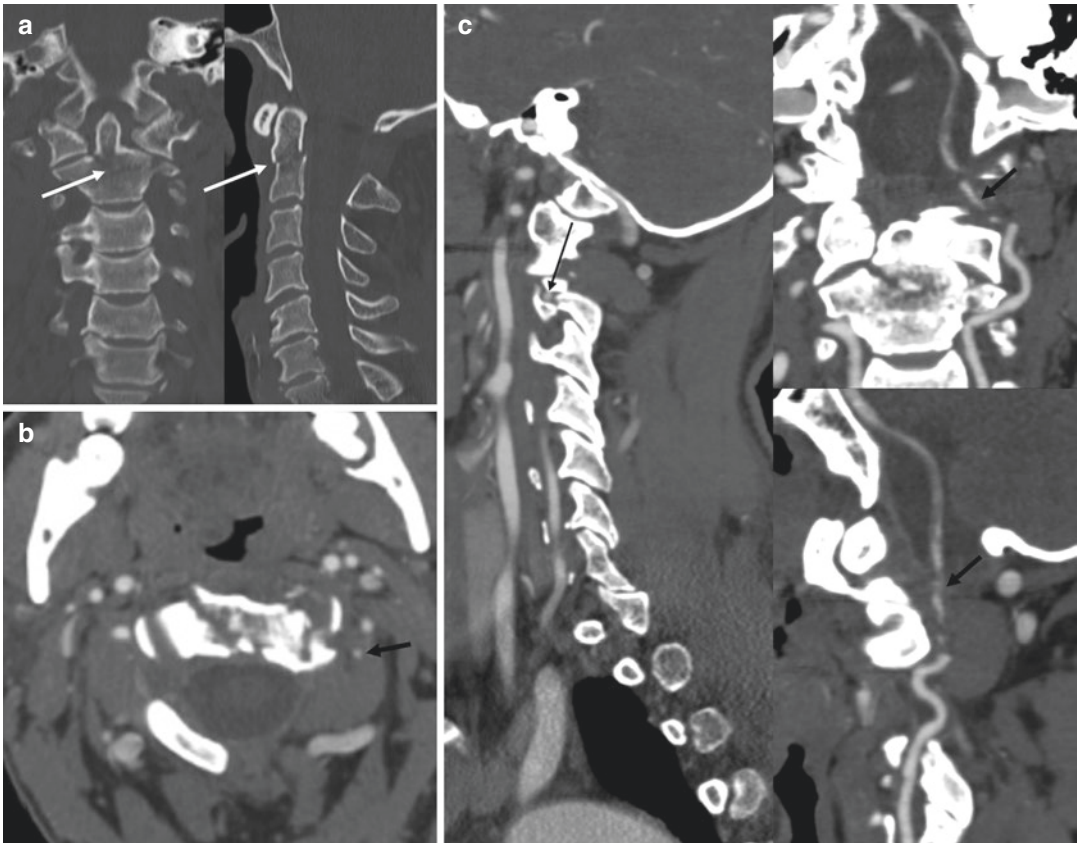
Fracture of C2 odontoid process (type III or “low”) and mass complicated by vertebral artery dissection: 2D-coronal and sagittal unenhanced CT (a), source axial (b), and 2D-reformatted sagittal and coronal CT angiography (c) images show the axis fracture (white
